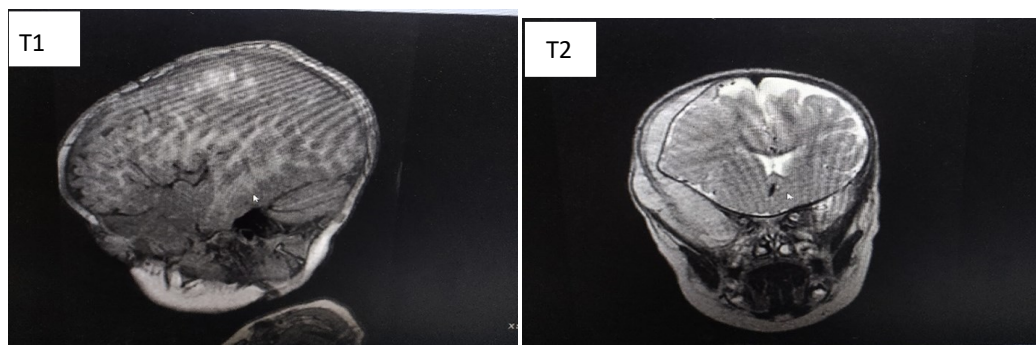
T1 and T2 coronal slice simple scanning MRI.
